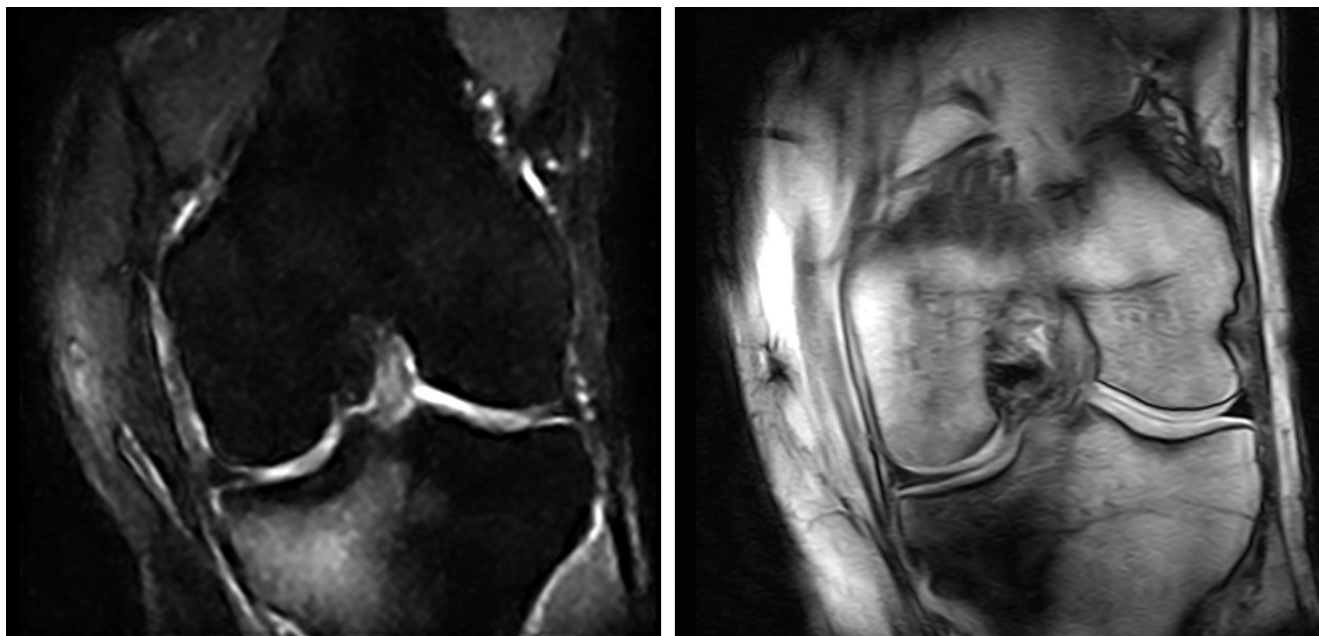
Magnetic resonance imaging of the left knee showing extensive bone marrow edema of the condylus tibialis.
